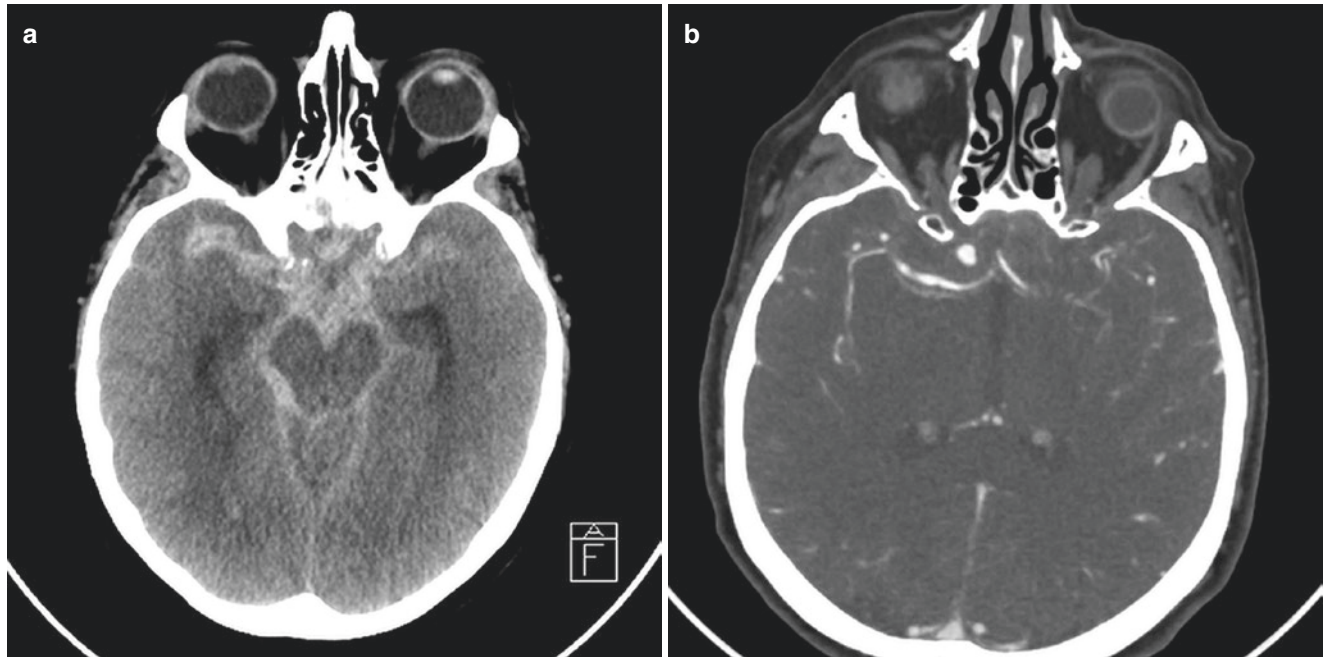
Ophthalmic aneurysm. (a) NCCT shows diffuse subarachnoid hemorrhage within the basal cisterns and bilateral Sylvian fissures, typical for aneurysm rupture. (b) Axial CTA shows a saccular aneurysm at the ophthalmic segment of right supraclinoid ICA
